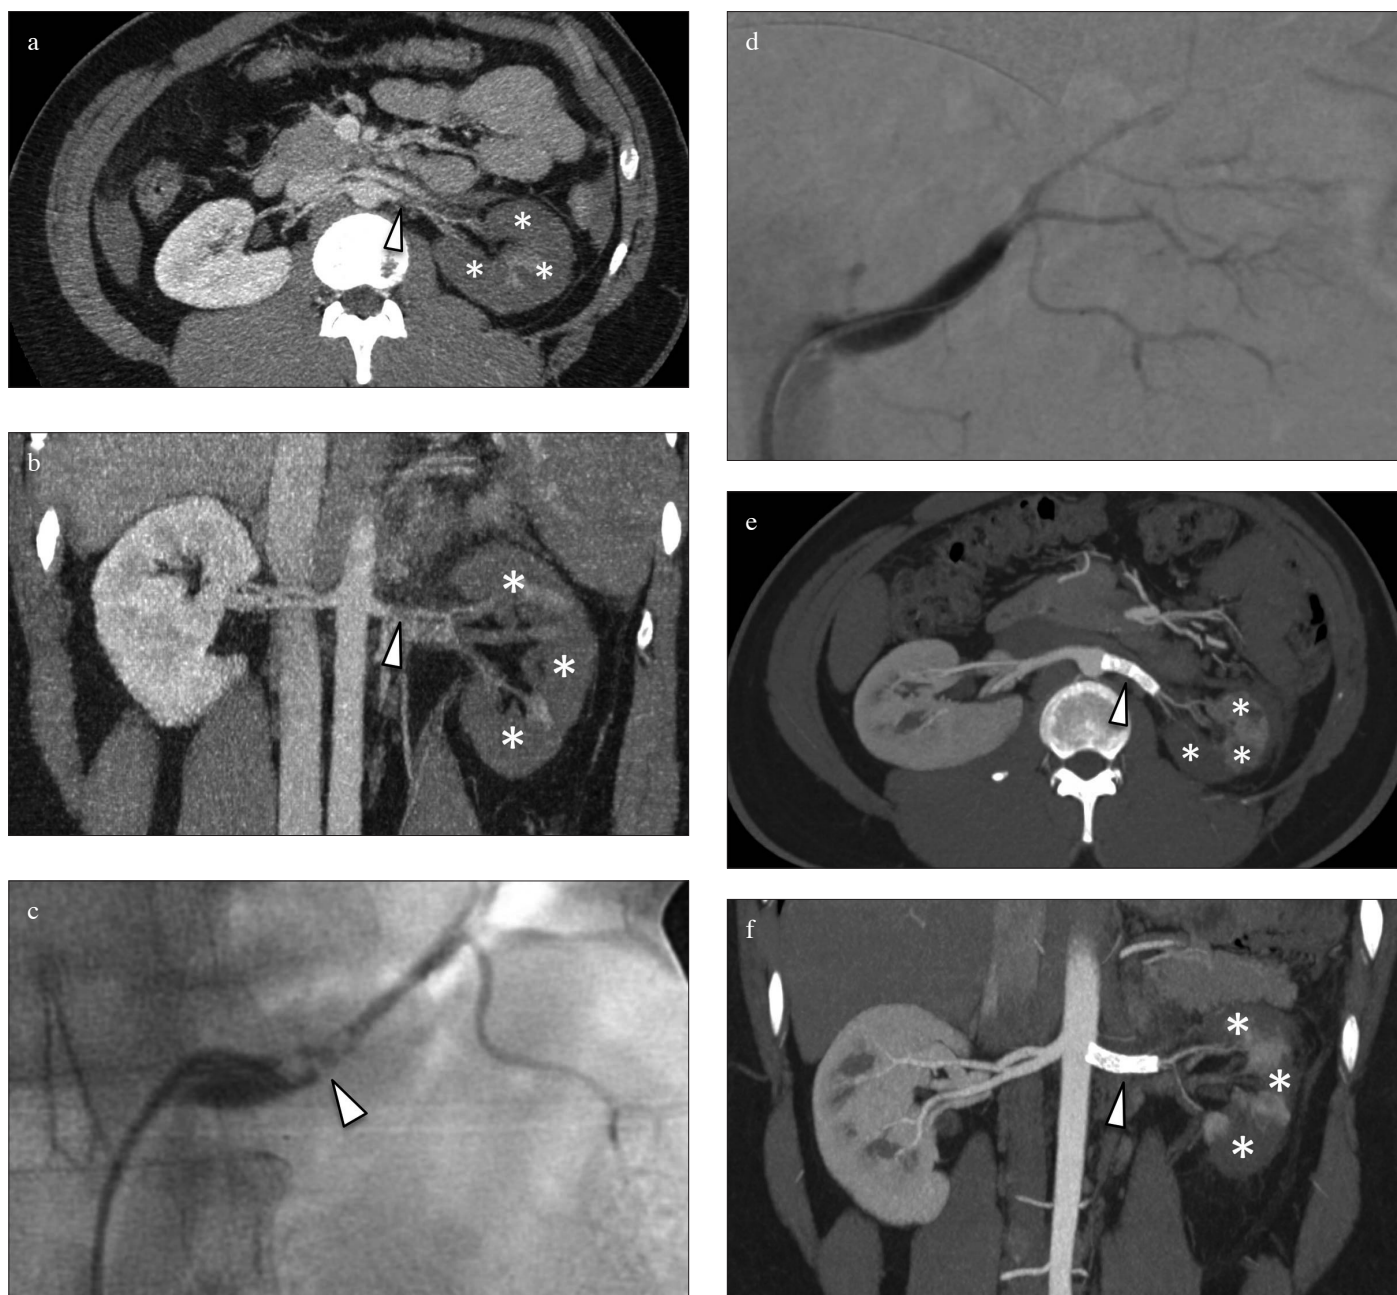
a-f. (a) Contrast-enhanced phase multi-detector computed tomograms of axial and (b) coronal reconstructions demonstrating left renal artery filling defect (arrowhead) and heterogenous parenchymal enhancement into the left kidney (\*). (c) Selective digital subtraction angiogram of the left renal artery demonstrating left renal arterial circular dissection (arrowhead) with reduced flow into the left kidney. (d) Selective digital subtraction angiogram of the left renal artery after deployment of the stents that demonstrates absence of intraluminal defects, normal flow into the stents, and substantially unchanged arterial blood flow into the left kidney. (e) Contrast-enhanced phase multi-detector computed tomograms of axial and (f) coronal reconstructions obtained at postprocedural 12 months demonstrating regular, unrestricted blood flow into the left renal artery stents (arrowhead) and partial vascularization of the diminished left kidney (\*)
